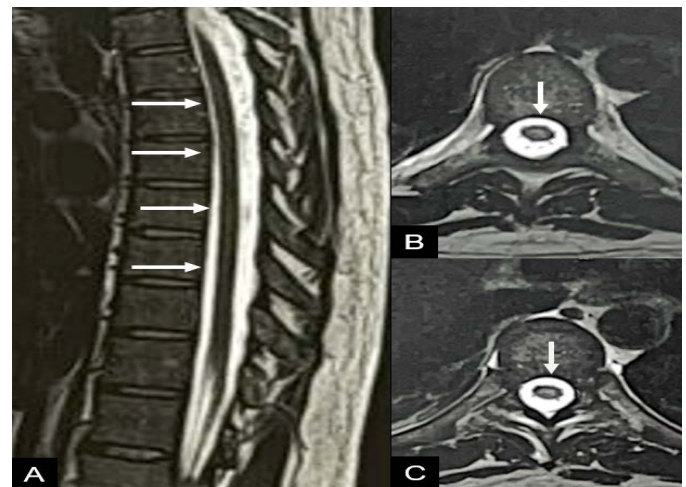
Sagittal (A) and axial (B) T2-weighted images of the thoracic spine, showing a slight area of signal alteration in the central portion of the spinal cord (arrows in A and B).
